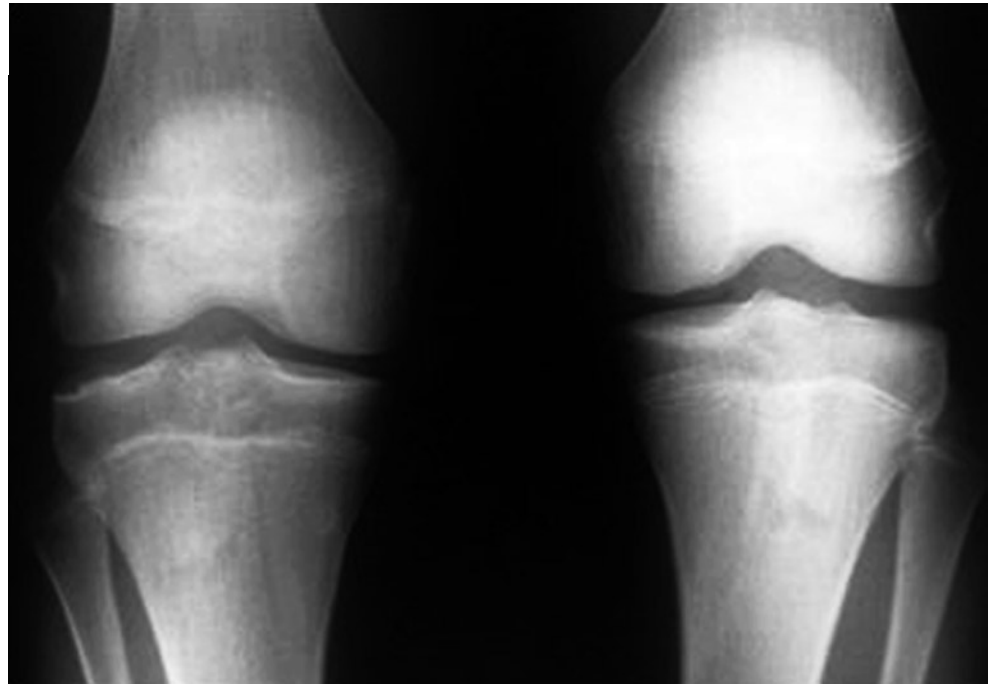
Lateral x-ray of the knee medial plateau with medial discoid menisci
